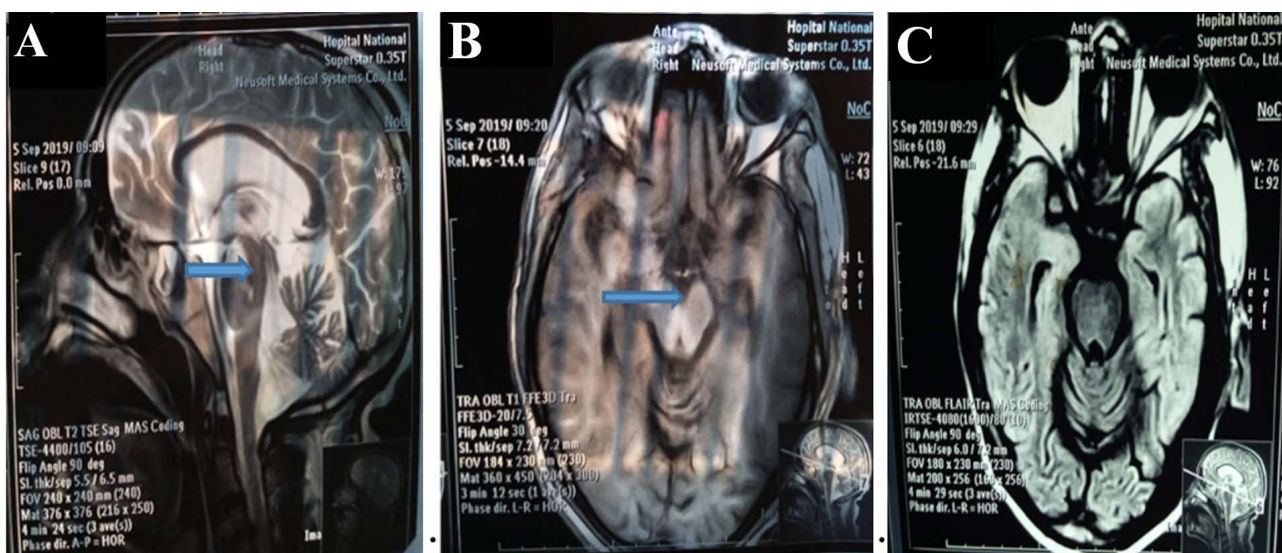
Brain MRI showing a protuberant hypersignal in T2-weighted sequence (A), Axial slice in T1 sequence showing a hyposignal at the level of the pons (B), Axial slice in FLAIR sequence (C).
